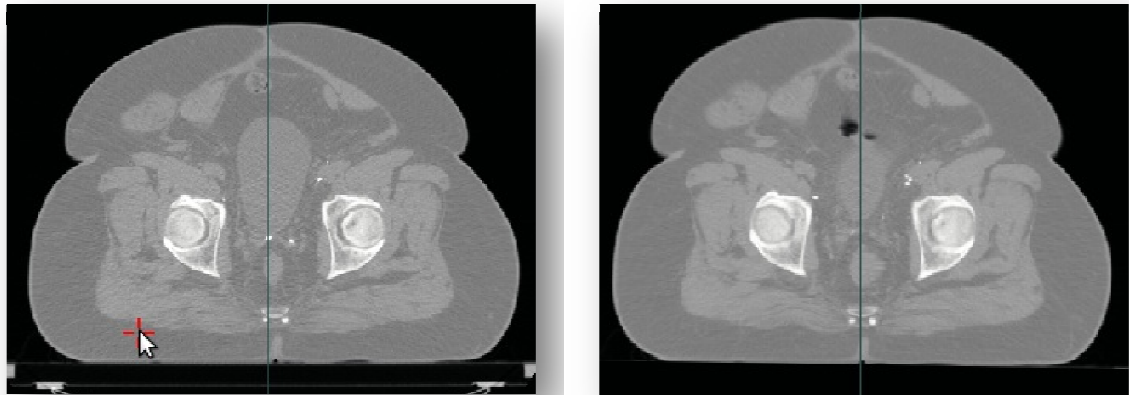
Planning CT image (left) and the CT image registered with the CBCT dataset (right).
